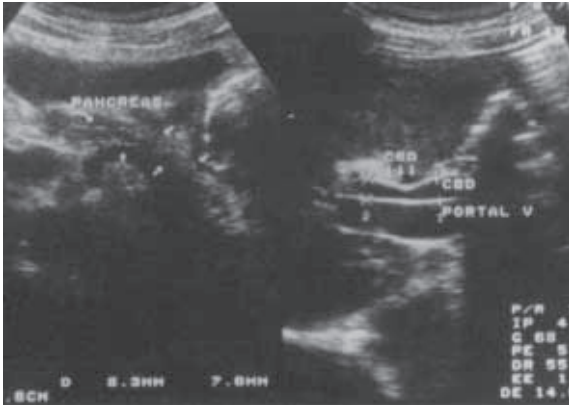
Ultrasonogram of Control 5 shows a CBD diameter of 2.5 mm.
